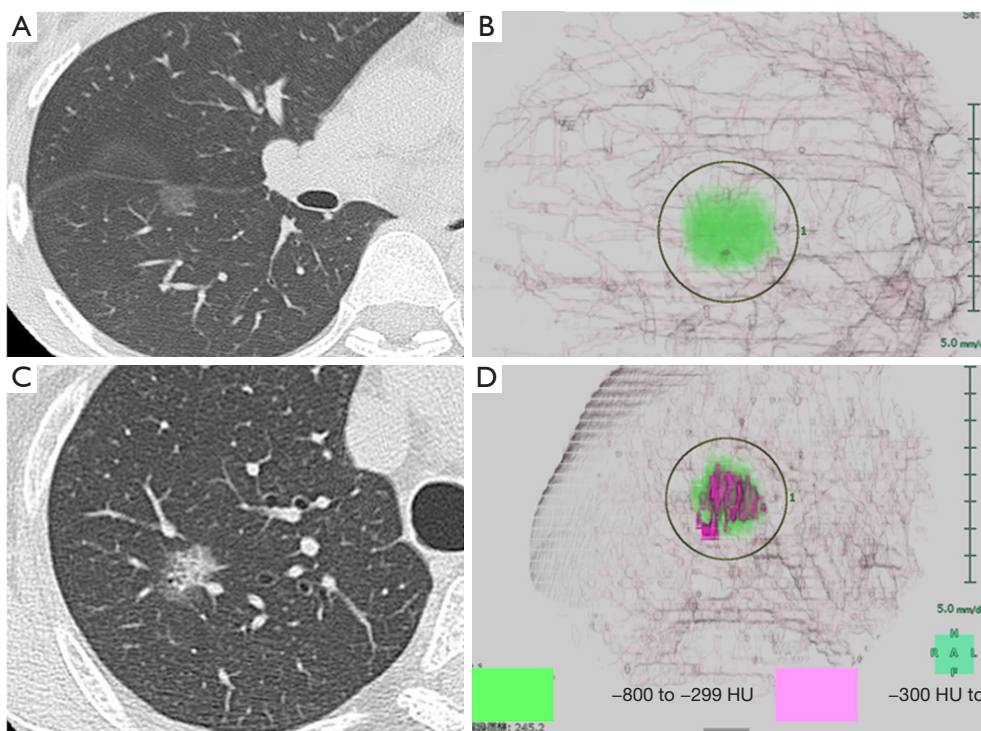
Representative images of axial-specific CT- and 3D-volume analyses. (A) An axial CT image. (B) A 3D image of a cTis/pTis case (TS =12 mm, SS =0 mm, SV =6.5 mm³, and IS =0 mm). (C) An axial CT image and (D) a 3D image of a cTis/pT1b case (TS =16 mm, SS =0 mm, SV =324 mm³, and IS =11 mm). HU, Hounsfield unit; CT, computed tomography; 3D, three-dimensional; TS, total size; SS, solid size; SV, solid volume; IS, invasive size.
